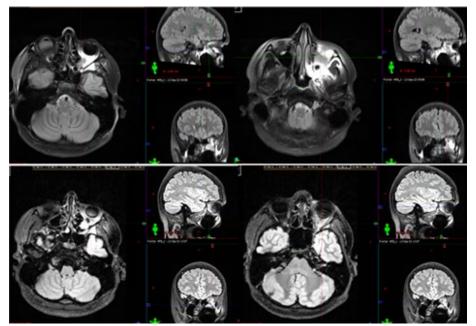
Axial MRI after completing 3 courses of chemotherapy/data on reverse development of thrombosis of dural venous sinuses with stasis of cortical veins on the convexity of the two large hemispheres. Data on reverse development of tracked parenchymal changes in the cortex and subcortical white matter of the left frontal lobe.
